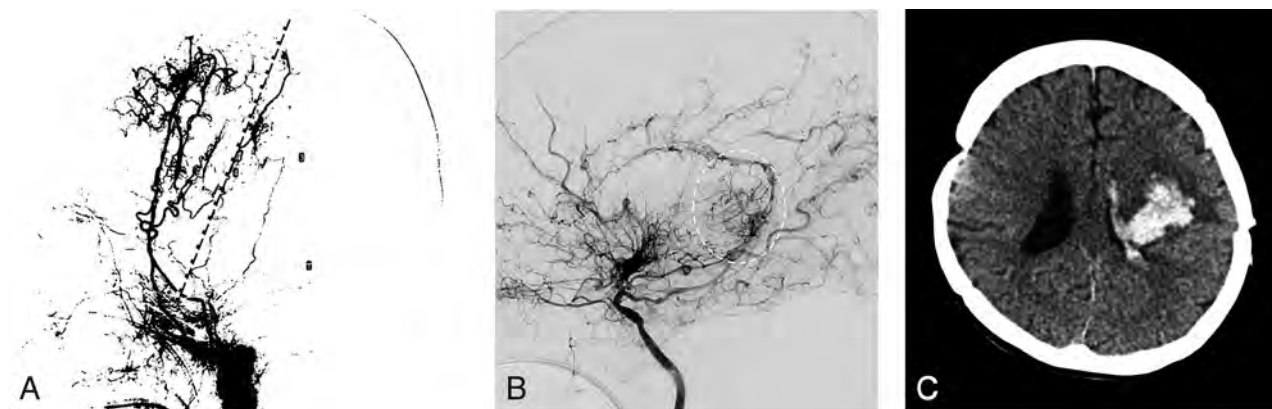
Case 2. The patient had initially manifested seizure at 43 years of age and had undergone direct bypass. *A*, Quantitative measurement of the revascularization area in the left hemisphere. The revascularization areas anterior and posterior to the CS were 12.3% and 1.5%, respectively. The dotted line indicates the CS. *B*, Postoperative left ICA shows persistence of choroidal anastomosis (dotted circle). *C*, CT obtained at the onset of de novo intracranial hemorrhage, which occurred 13 years after the operation.
